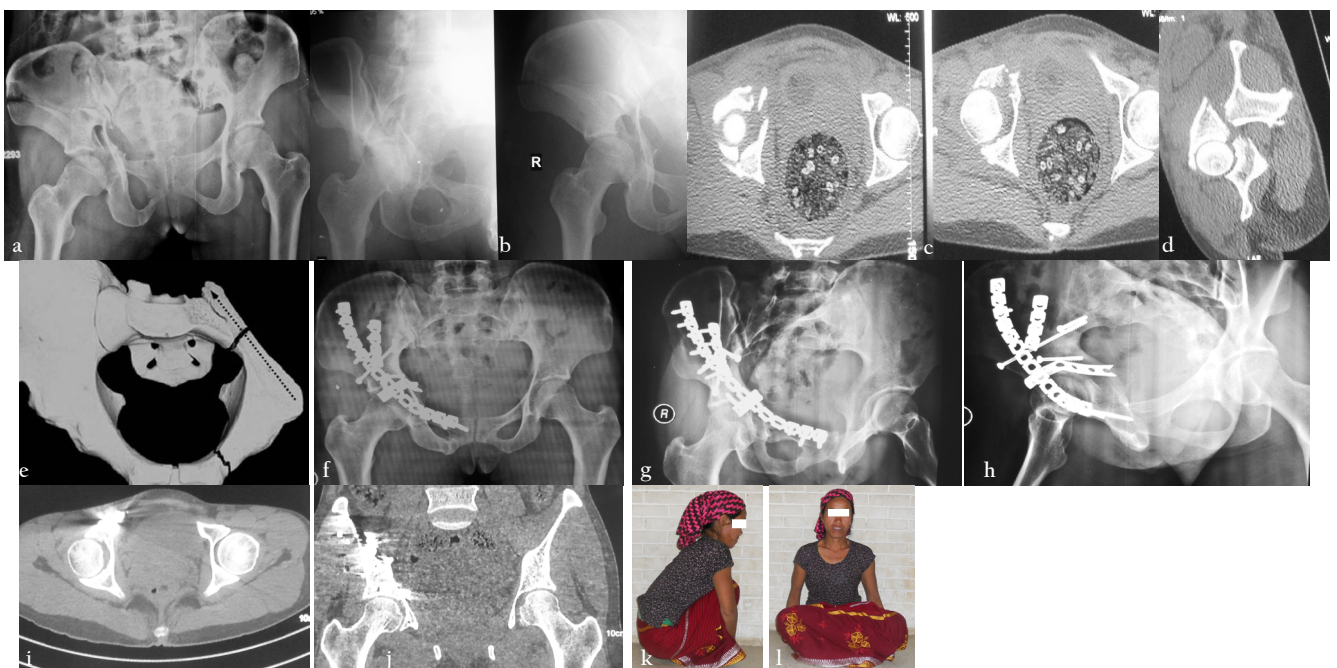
Bicolumnar fracture with high/middle anterior column with pregnancy fixed with LCII screw. a to d: Pre operative X-rays and CT scan, e: Trajectory of screw for LC II screw, f to i: Follow up X-rays and CT scan and clinical picture at 24 months
